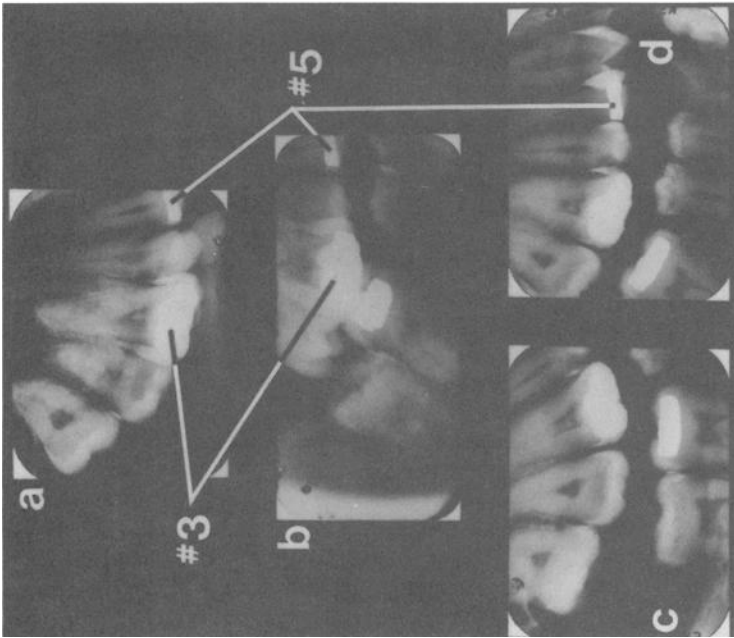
The postmortem and antemortem dental radiographs of the right maxilla and mandible of Lee Harvey Oswald: (a, b, and d) postmortem radiographs, 4 Oct. 1981 and (b) antemortem radiograph, 27 March 1958. No. 3 Maxillary right first molar—restorations demonstrate more similar radiographic morphology when antemortem duplication (b) is duplicated in (a) versus that in (c) and (d). No. 5 Maxillary right first premolar—restoration demonstrates identical radiographic morphology in all radiographs.
